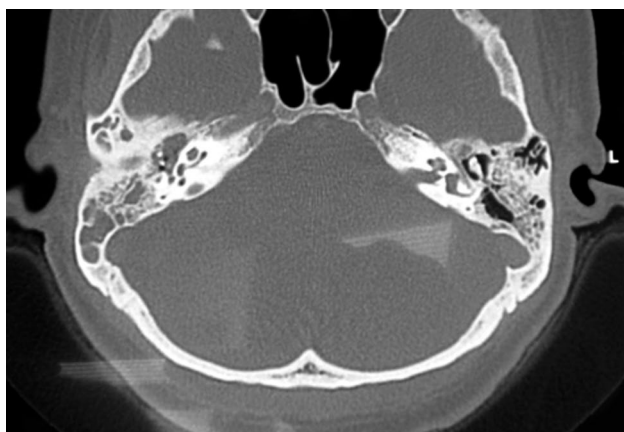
Axial computed tomography scan showing mucosal thickening and loss of aeration, without bone erosion
